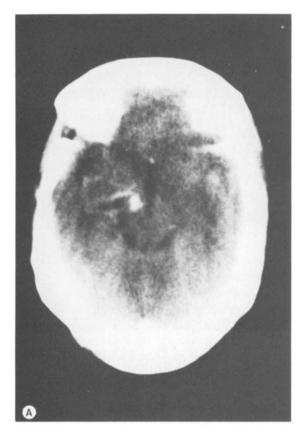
Enhanced CT scans. A: after the fourth course of chemotherapy and B: after the sixth course of chemotherapy. Notice the progressive negative attenuation values within the cyst with a peripheral hyperdense rim.
